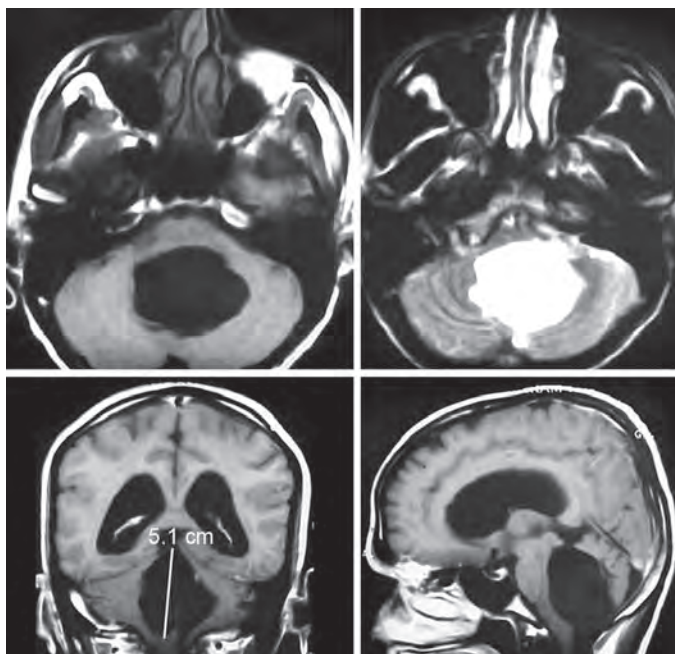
MRI of the brain showing fourth ventricular epidermoid causing pressure over the brainstem
